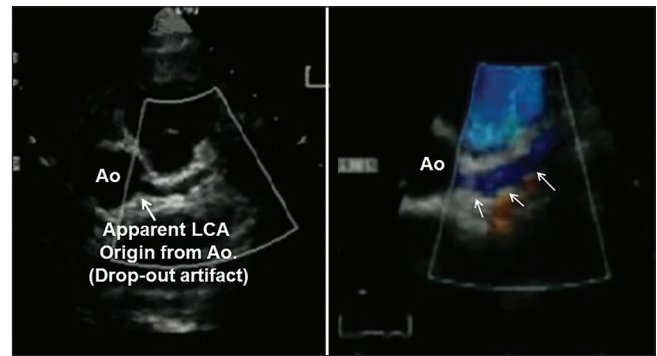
Echocardiogram in parasternal short-axis view from case 2 (14 year old). Panel 3A shows 2D image of aortic root in cross-section with apparent origin of left coronary artery (LCA) from aorta. Arrow points to area of "drop-out" artifact. Panel 3B shows color Doppler imaging of the same area. Blue color indicates reversed direction of flow in left coronary artery (arrows) which is abnormal
